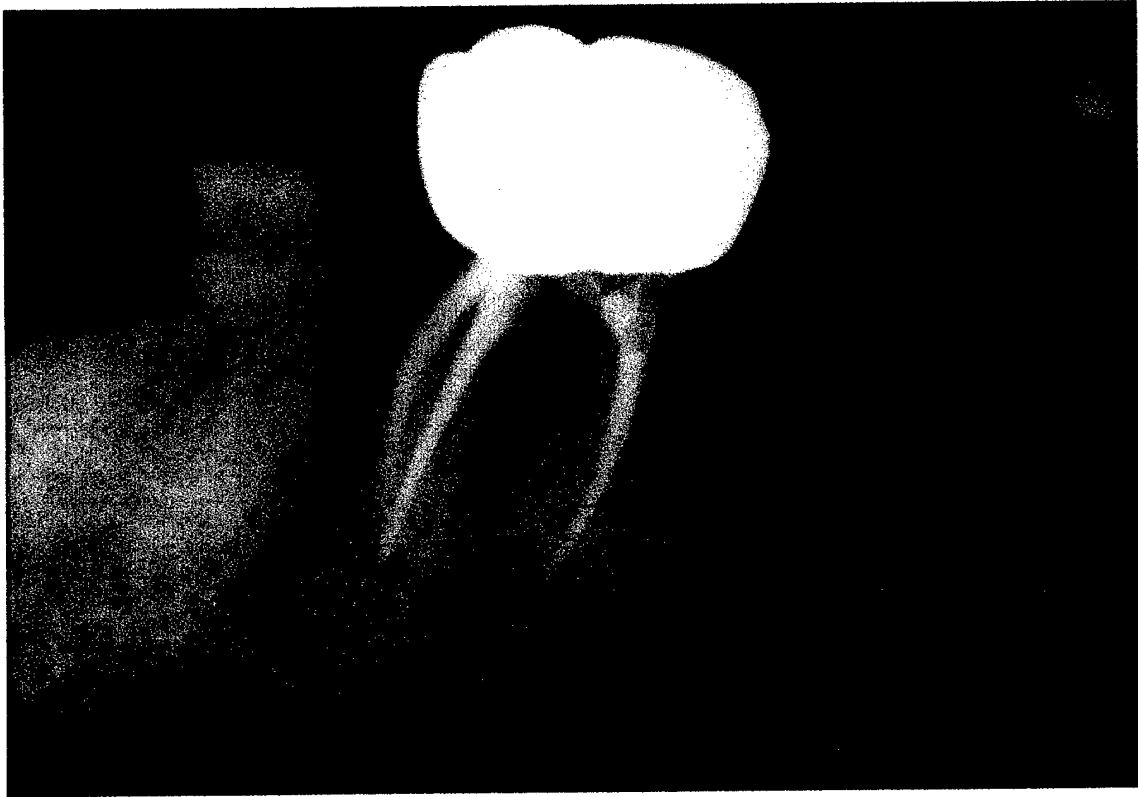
Test image with periapical lesion 0.1 mm to 2.0 mm in diameter associated with root identified by digital marker.
